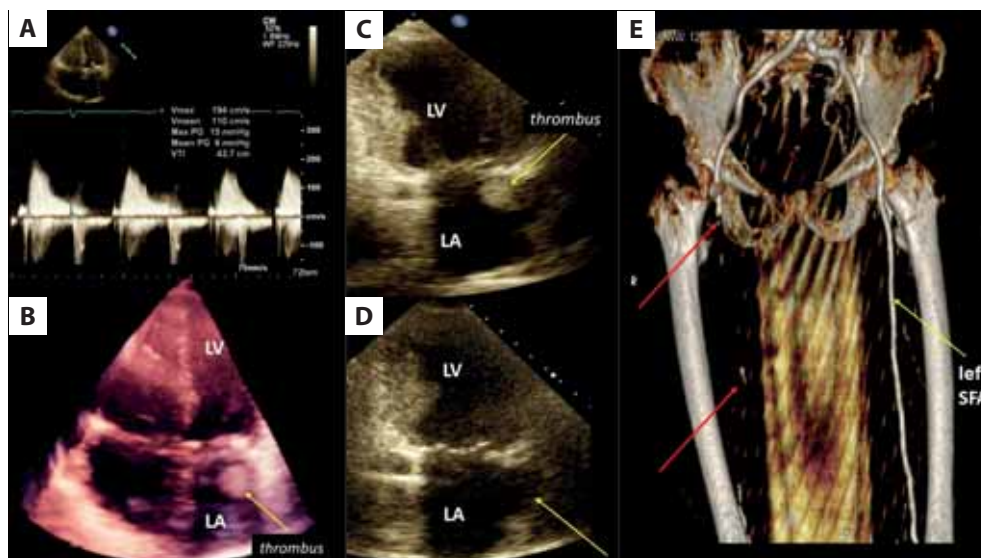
A. Transmitral mean gradient (6 mm Hg) indicating moderate mitral stenosis; continuous wave Doppler; B. Additional mass (thrombus) visible in the slightly enlarged left atrium (the arrow); 3DTTE, four-chamber view; C. Additional structure (thrombus) fixed in the place of the left atrium appendage (the arrow); 2D TTE, two-chamber view; D. Absence of pathological mass in the area of the left atrium appendage (the arrow); 2D TTE, two-chamber view; E. Lower-extremity computed tomographic angiography showing occlusion of the distal part of the right common femoral artery, right superficial femoral artery and deep femoral artery (red arrows). Normal flow in the left superficial femoral artery (yellow arrow)
